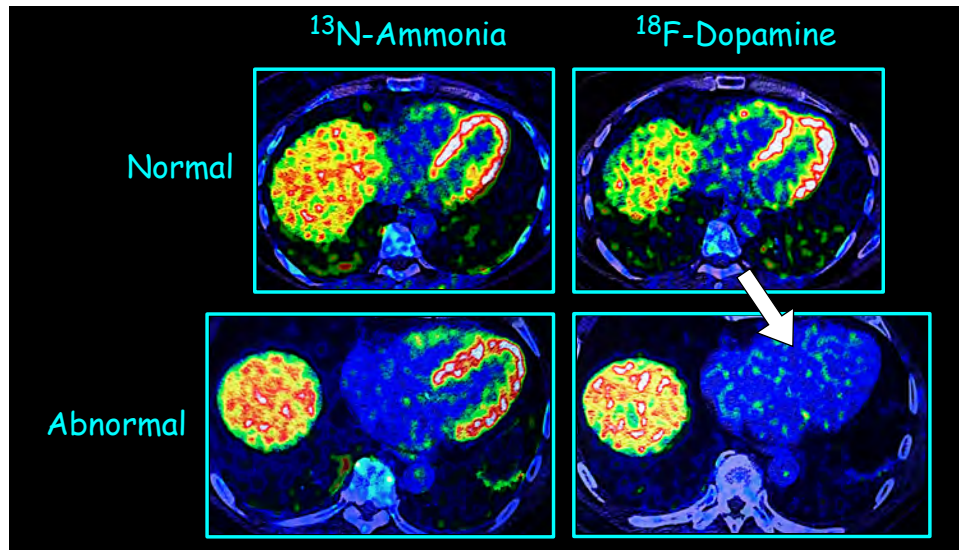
^{13}N -Ammonia and ^{18}F -dopamine PET/CT scans in (left) a control subject and (right) a patient with a Lewy body form of neurogenic orthostatic hypotension (nOH). Both patients have normal myocardial ^{13}N -ammonia perfusion scans. In the patient with the abnormal ^{18}F -dopamine scan (arrow) the liver is seen well, but the left ventricular myocardium is not seen at all (white arrow).
